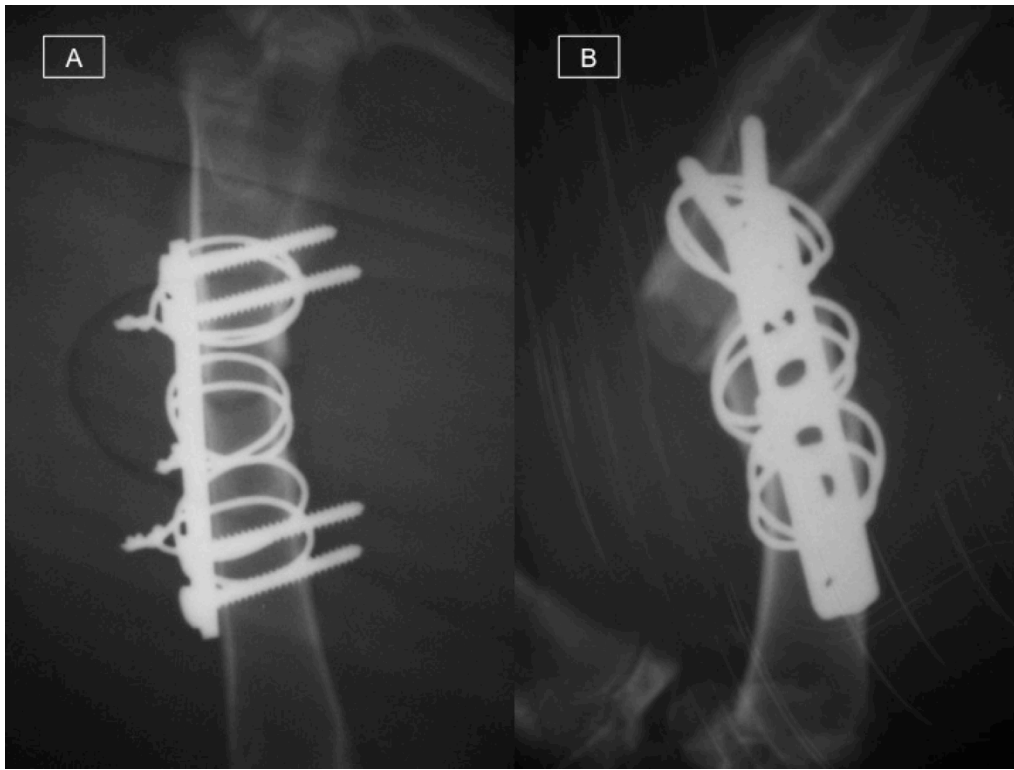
Xray of the femoral allograft fixed with 6 holes DCP plate, screws and metallic cable wires. A) Post operative check, with satisfactory position of the allograft and apparent satisfactory fixation. B) 1 week post-operative Xray check, loss of fixation at the proximal osteotomy.
